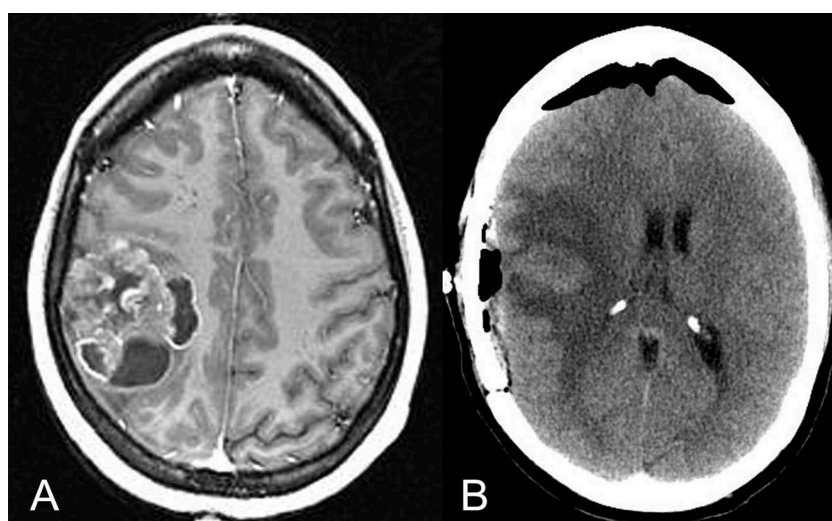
A) Enhanced pre-operative MRI of 35-year-old woman with anaplastic ependymoma. B) CT done 4 hours post-operatively after awake craniotomy and 2 hours prior to discharge from the DSU.
